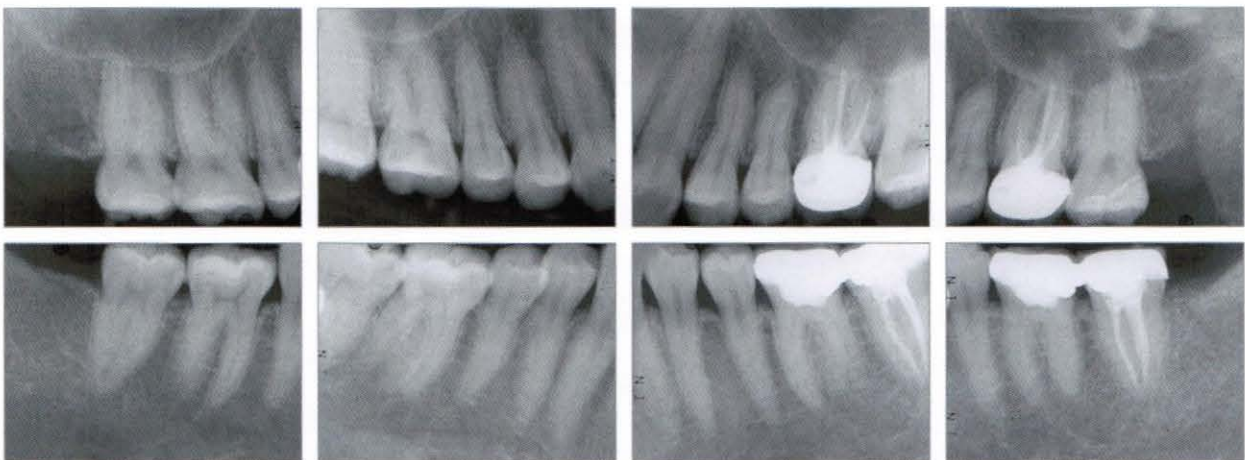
Periapical radiograph to check the distance between roots
